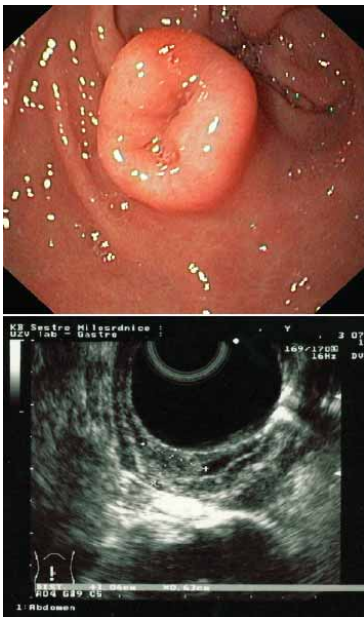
Antral heterotopic pancreas seen as an umbilicated lesion on endoscopy. Endosonographically it appears as an isoechoic lesion with a slightly inhomogenous texture arising from the second layer.
